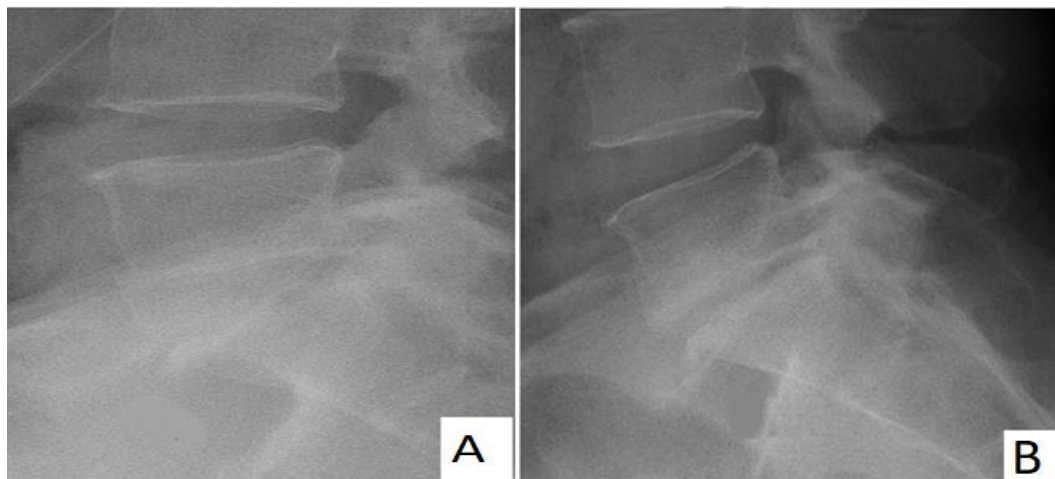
A One month follow up X-ray, B: follow up x-ray after 3 months. VAS score = 3. Frankle scale was improved from C to D.
